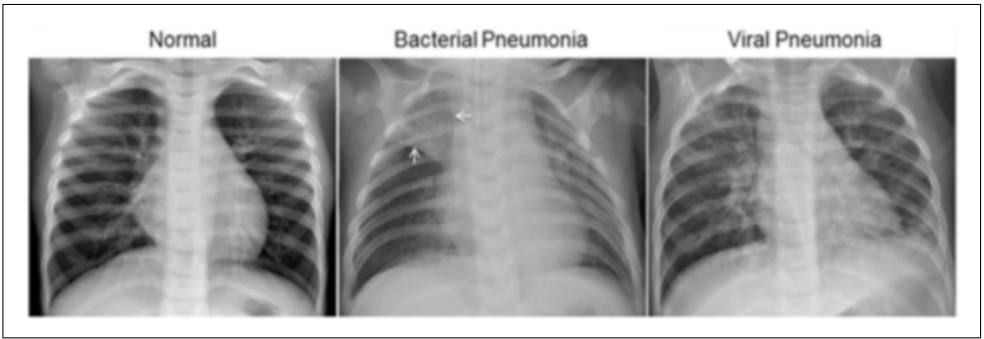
Difference in X-Ray Scans of healthy lungs, Bacterial Pneumonia infected lungs, Viral Pneumonia infected lungs
